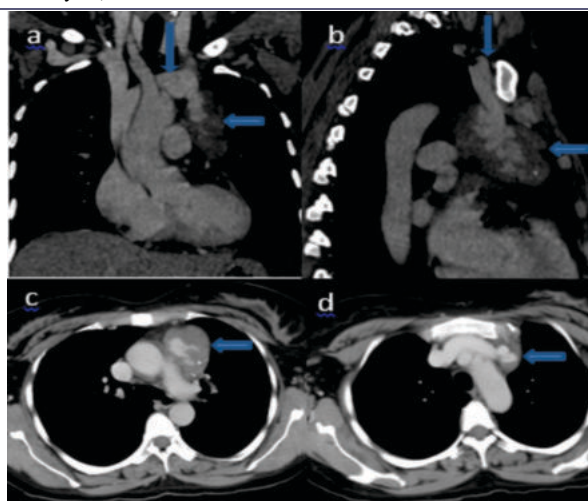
Coronal (a), sagittal (b) and axial images (c,d) of the contrast CT show the partially thrombosed saccular aneurysm (arrows) communicating with the left innominate vein.
